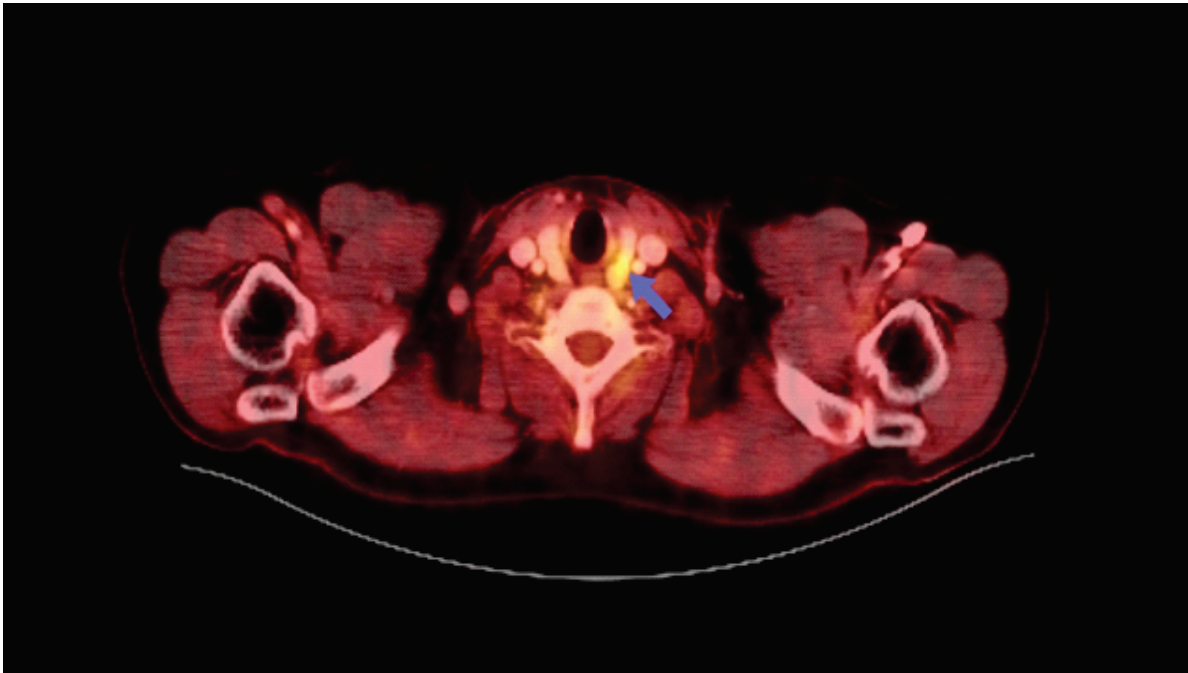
PET-CT Neck showing the FGD uptake in the left superior parathyroid gland.
